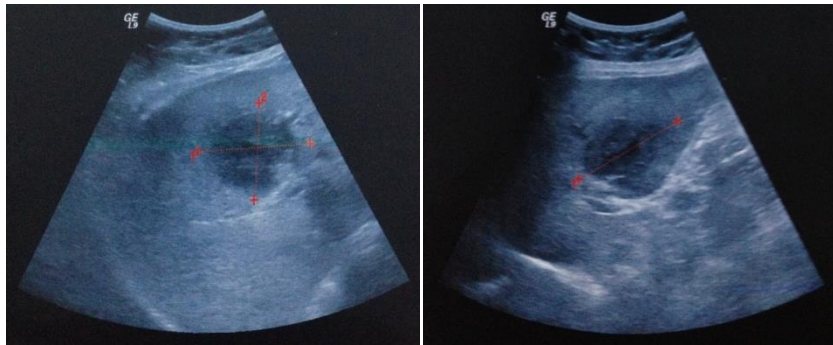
image of the abdominal ultrasound showing heterogeneous hypoechoic hepatic formation
